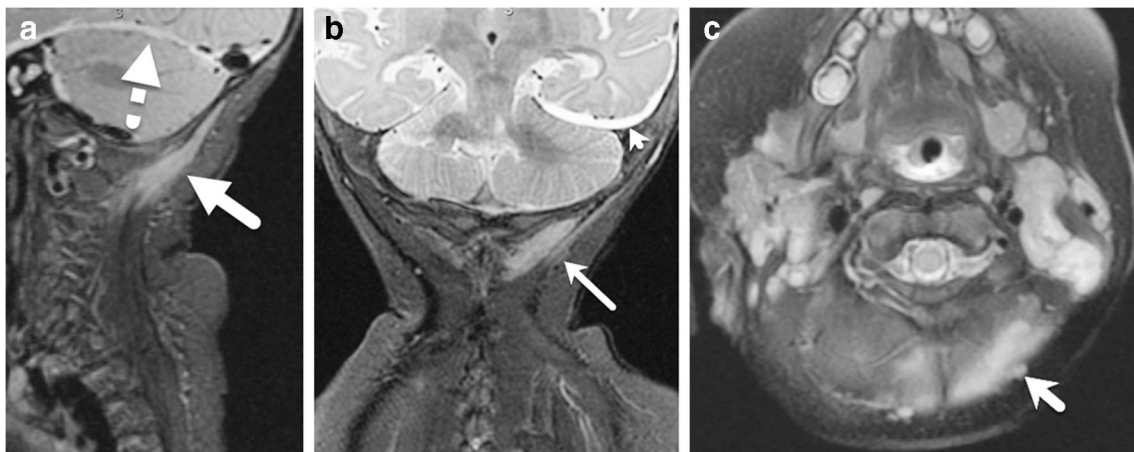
Suboccipital musculature injury in a 4-month-old girl with abusive head trauma. a Sagittal short tau inversion recovery (STIR) MR image of the cervical spine demonstrates evidence of injury to the suboccipital musculature, which is primarily asymmetrical in nature and centered over the left suboccipital region (*solid arrow*). This might represent asymmetrical force of the injury or contusion from an impact injury. A T2-hyperintense subdural hemorrhage (SDH) is identified along the left
